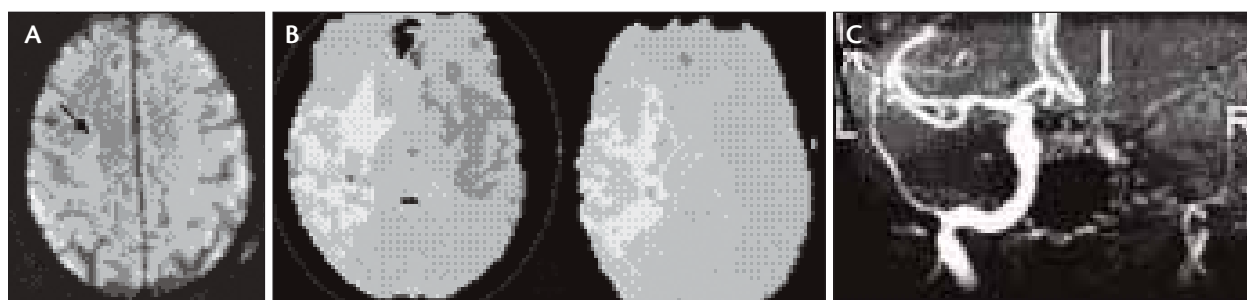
Magnetic resonance imaging (MRI). MR diffusion showing a small area stroke (arrow) (A). MR perfusion showing a large right hemispheric perfusion defect (B). MR angiogram with occlusion of right internal carotid artery and no-filling right middle cerebral artery; both anterior cerebral arteries fill from the left internal carotid artery (C).
